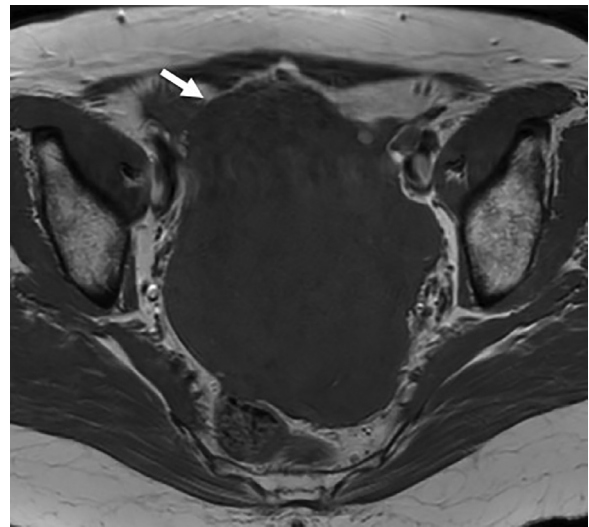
Axial T1-weighted image shows a well-defined isointense mass (white arrow) located in the pelvis.
